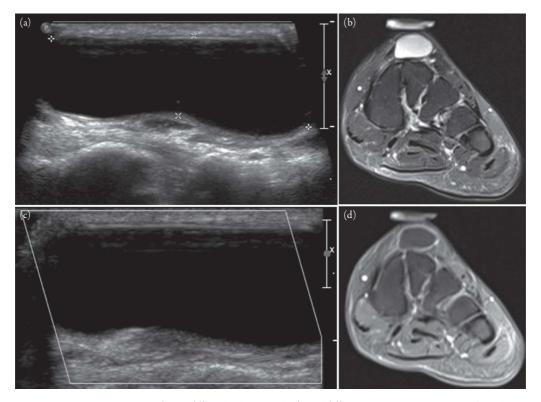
Ganglion cyst of the foot. Grayscale (Panel (a)) and color Doppler (Panel (b)) images in transverse plane of the dorsal mid-foot show a circumscribed anechoic subcutaneous soft tissue mass with posterior acoustic enhancement and no internal flow. Corresponding fluid sensitive (Panel (c)) and contrast-enhanced (Panel (d)) magnetic resonance images show a cystic dorsal mid foot mass that meets criteria for a simple cyst with only minimal peripheral enhancement.
